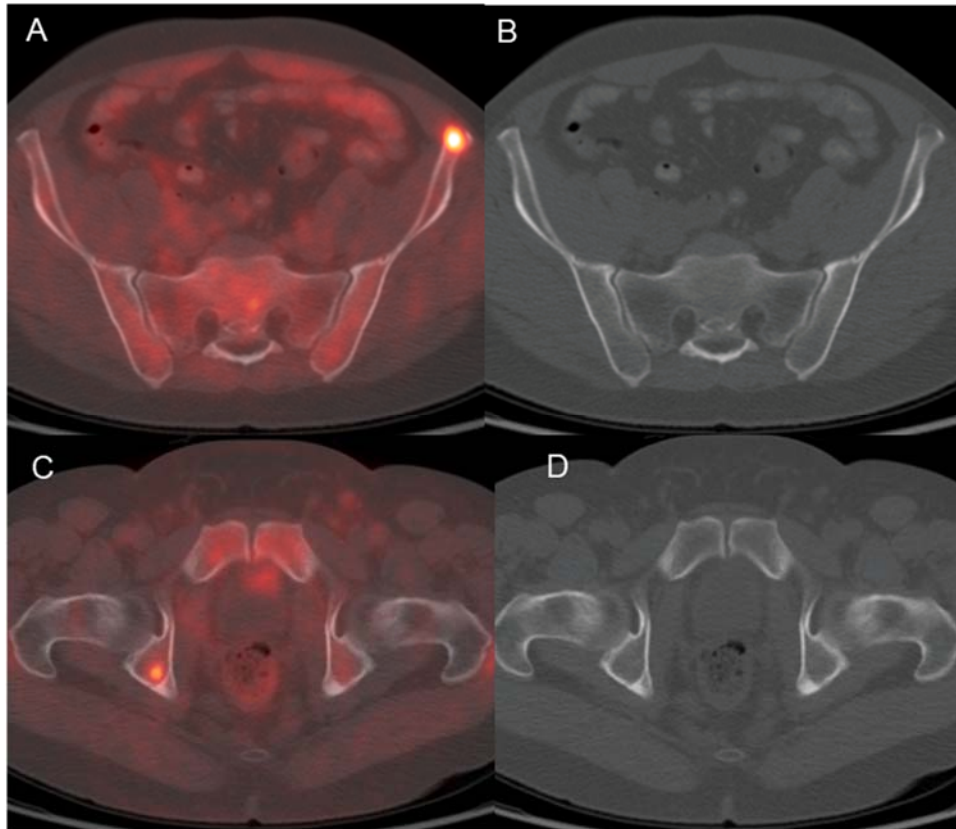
50 year old male with biochemical recurrence of prostate cancer after prostatectomy (PSA of 3.2 ng/mL; doubling time of 1.4 months). MRI of abdomen initially read as negative and subsequent ^{18}F -fluciclovine PET-CT found multiple osseous metastases. Transaxial fluciclovine PET-CT through subtle left iliac bone lytic lesion (A) fused, (B) CT. Transaxial fluciclovine PET-CT through silent right acetabular lesion(C) fused, (D) CT
